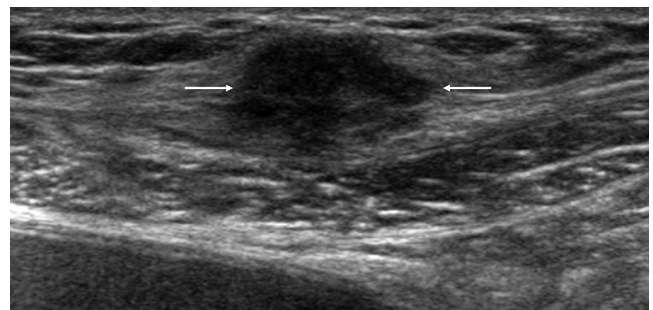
Abdominal wall endometriosis. Longitudinal sonogram at the suprapubic region of a 50-year-old woman who had cyclic pain over the hysterectomy scar. An irregular hypoechoic mass is present in the subcutaneous tissues deep to the cutaneous scar suggestive of endometriosis (arrows), which was confirmed by ultrasound-guided biopsy.
